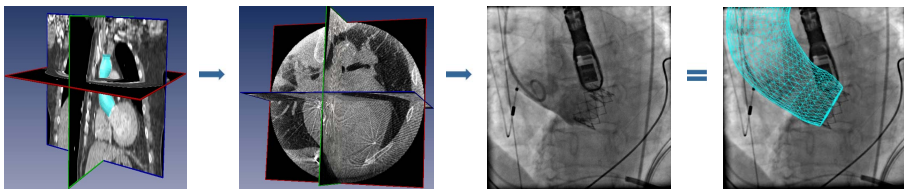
Non-contrasted C-arm CT based fusion of the aortic root model to provide visual guidance for transcatheter aortic valve implantation. Left: Pre-operative 3D CT with the automatically segmented aortic root mesh. Left Middle: Intra-operative non-contrasted C-arm CT. Right Middle: A 2D fluoroscopic image. Right: Model fusion result.
